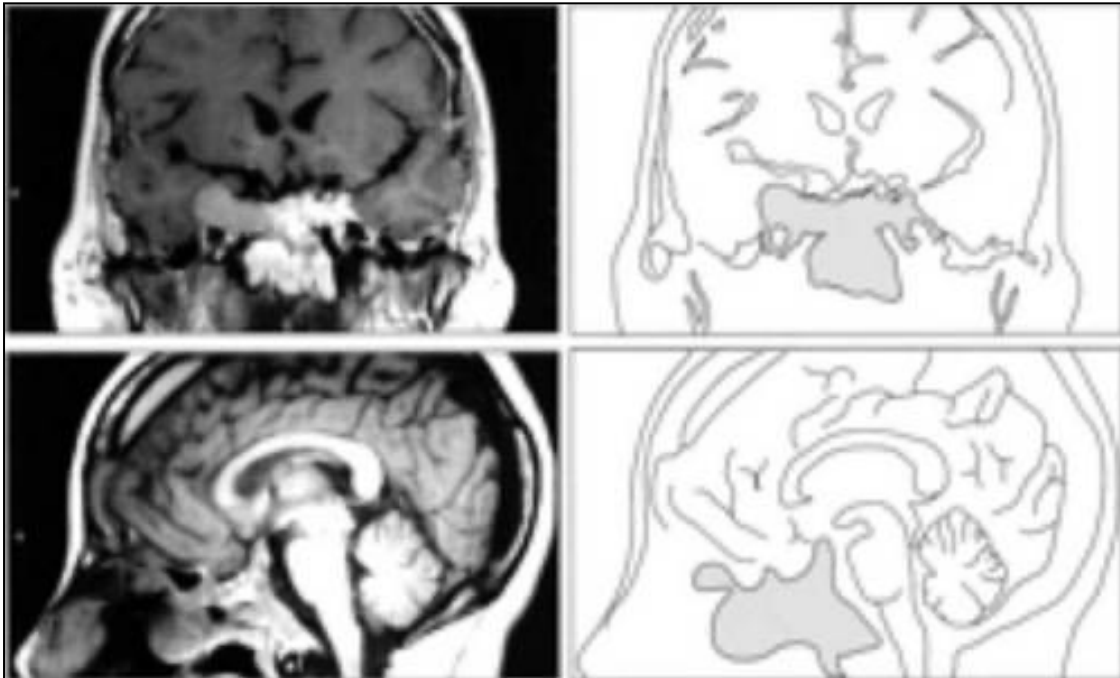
The extent of tumor invasion as visualized with coronal and lateral MRI views and their outlines. Reproduced from (165) with permission.
